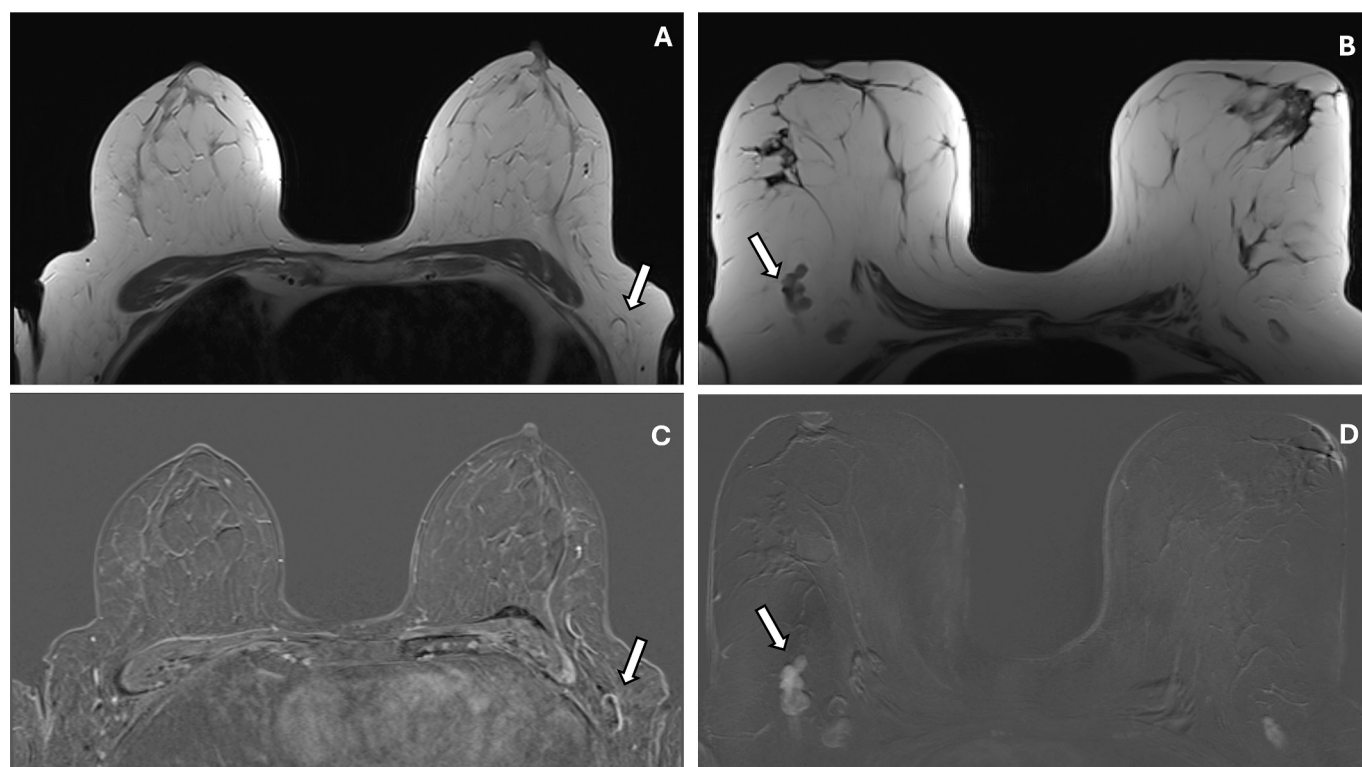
Node-RADS 1* (A, C) – 44-year-old woman with grade 1 invasive breast carcinoma of no special type (IBC-NST) in the left breast undergoing preoperative MRI. (A) Axial T2-weighted image shows an oval lymph node with smooth borders and preserved fatty hilum (arrow); (C) Axial subtracted contrast-enhanced T1-weighted image confirms normal size and shows homogeneous enhancement (arrow). These features are consistent with *Node-RADS 1*. *Node-RADS 5* (B, D) – 56-year-old woman with multifocal grade 2 IBC-NST in the right breast undergoing preoperative MRI. (B) Axial T2-weighted image shows a bulky lymph nodal mass (arrow); (D) Axial subtracted contrast-enhanced T1-weighted image confirms these findings (arrow). These features are consistent with *Node-RADS 5*.
